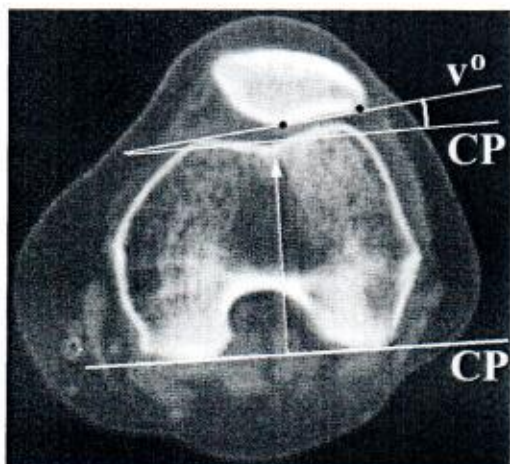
Measurement at CT of the lateral patellofemoral angle (v°) relative to the femoral condylar plane (CP)
